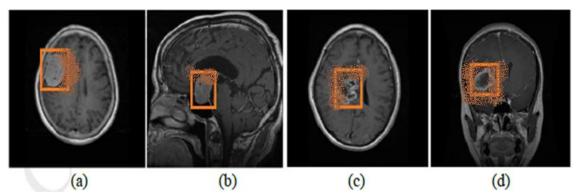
Images of brain tumors in T1-weighted CE-MRI. The area inside the rectangle is where the nanodrug is applied. (a) Meninges are located near the skull, (b) Pituitary gland is located near the sphenoid sinus; (c) Glioma containing edema and necrosis; and (d)
